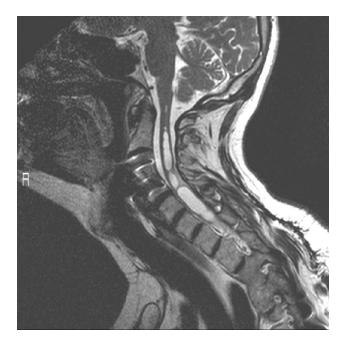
Nine months following a motor vehicle accident with upper thoracic fractures and level T-3 complete paraplegia, this patient presented with an ascending sensory level and increasing left hand weakness. Magnetic resonance imaging demonstrated a posttraumatic syrinx extending from the C-1 level through the conus.
